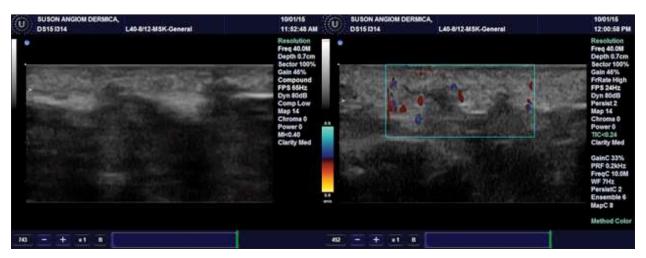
HFUS images performed over the sub-umbilical region demonstrates small hernias of the hypodermis in the hyperechoic suprajacent dermis associated with increased vascular flow on Color Doppler.
